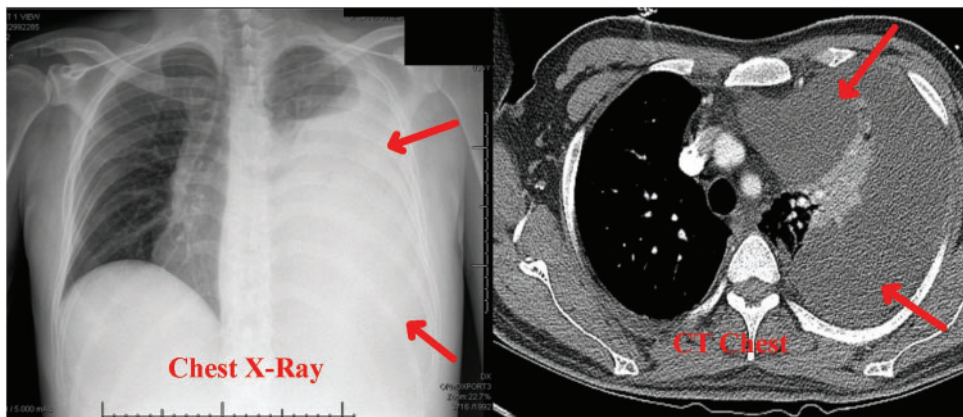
Chest x-ray and computerized tomography (CT) performed during admission showed near complete left-sided pleural effusion (arrows) with atelectatic changes.
